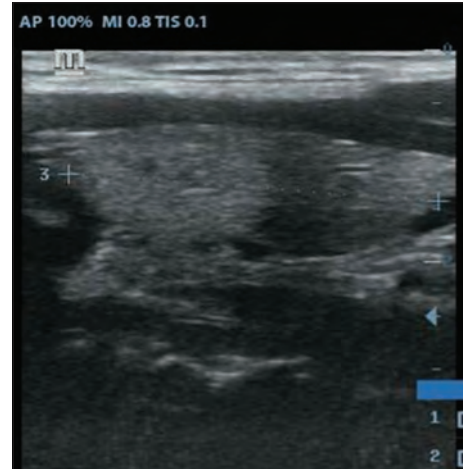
Longitudinal B-mode sonogram showing measurement of the right thyroid lobe's craniocaudal diameter (length)
